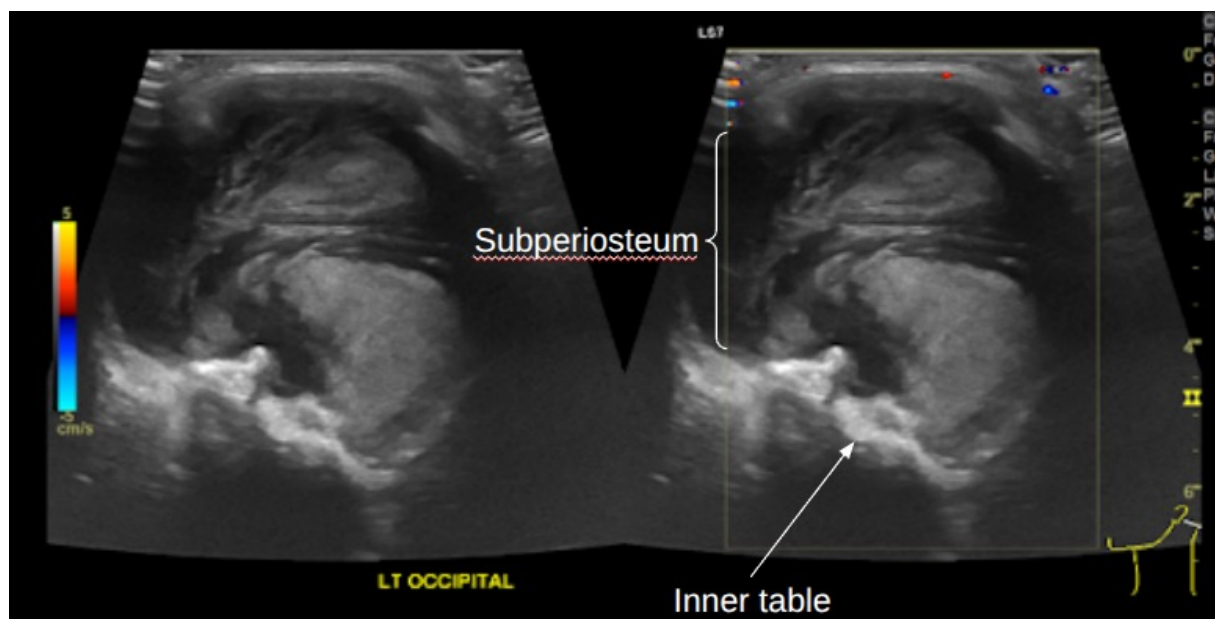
Ultrasound image shows (A) grey scale, (B) with color Doppler showing a heterogeneous hypo-hyperechoic mass in the left occipital region with an anechoic component involving the subperiosteal region (shown by bracket), with extension to the diploe of the occipital skull. There was no intralesional vascularity.
